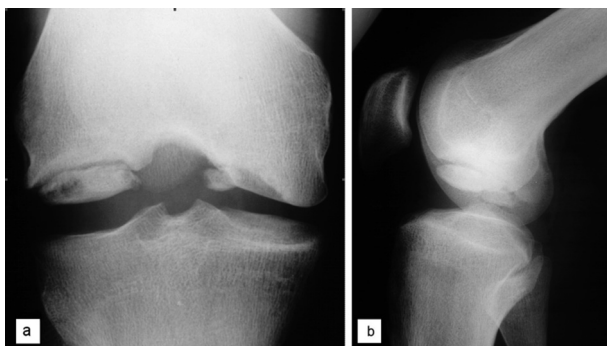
Antero-posterior (a) and lateral (b) plain radiographs of the right knee that showed existence of huge osteochondritis dissecans defects in both femoral condyles.
